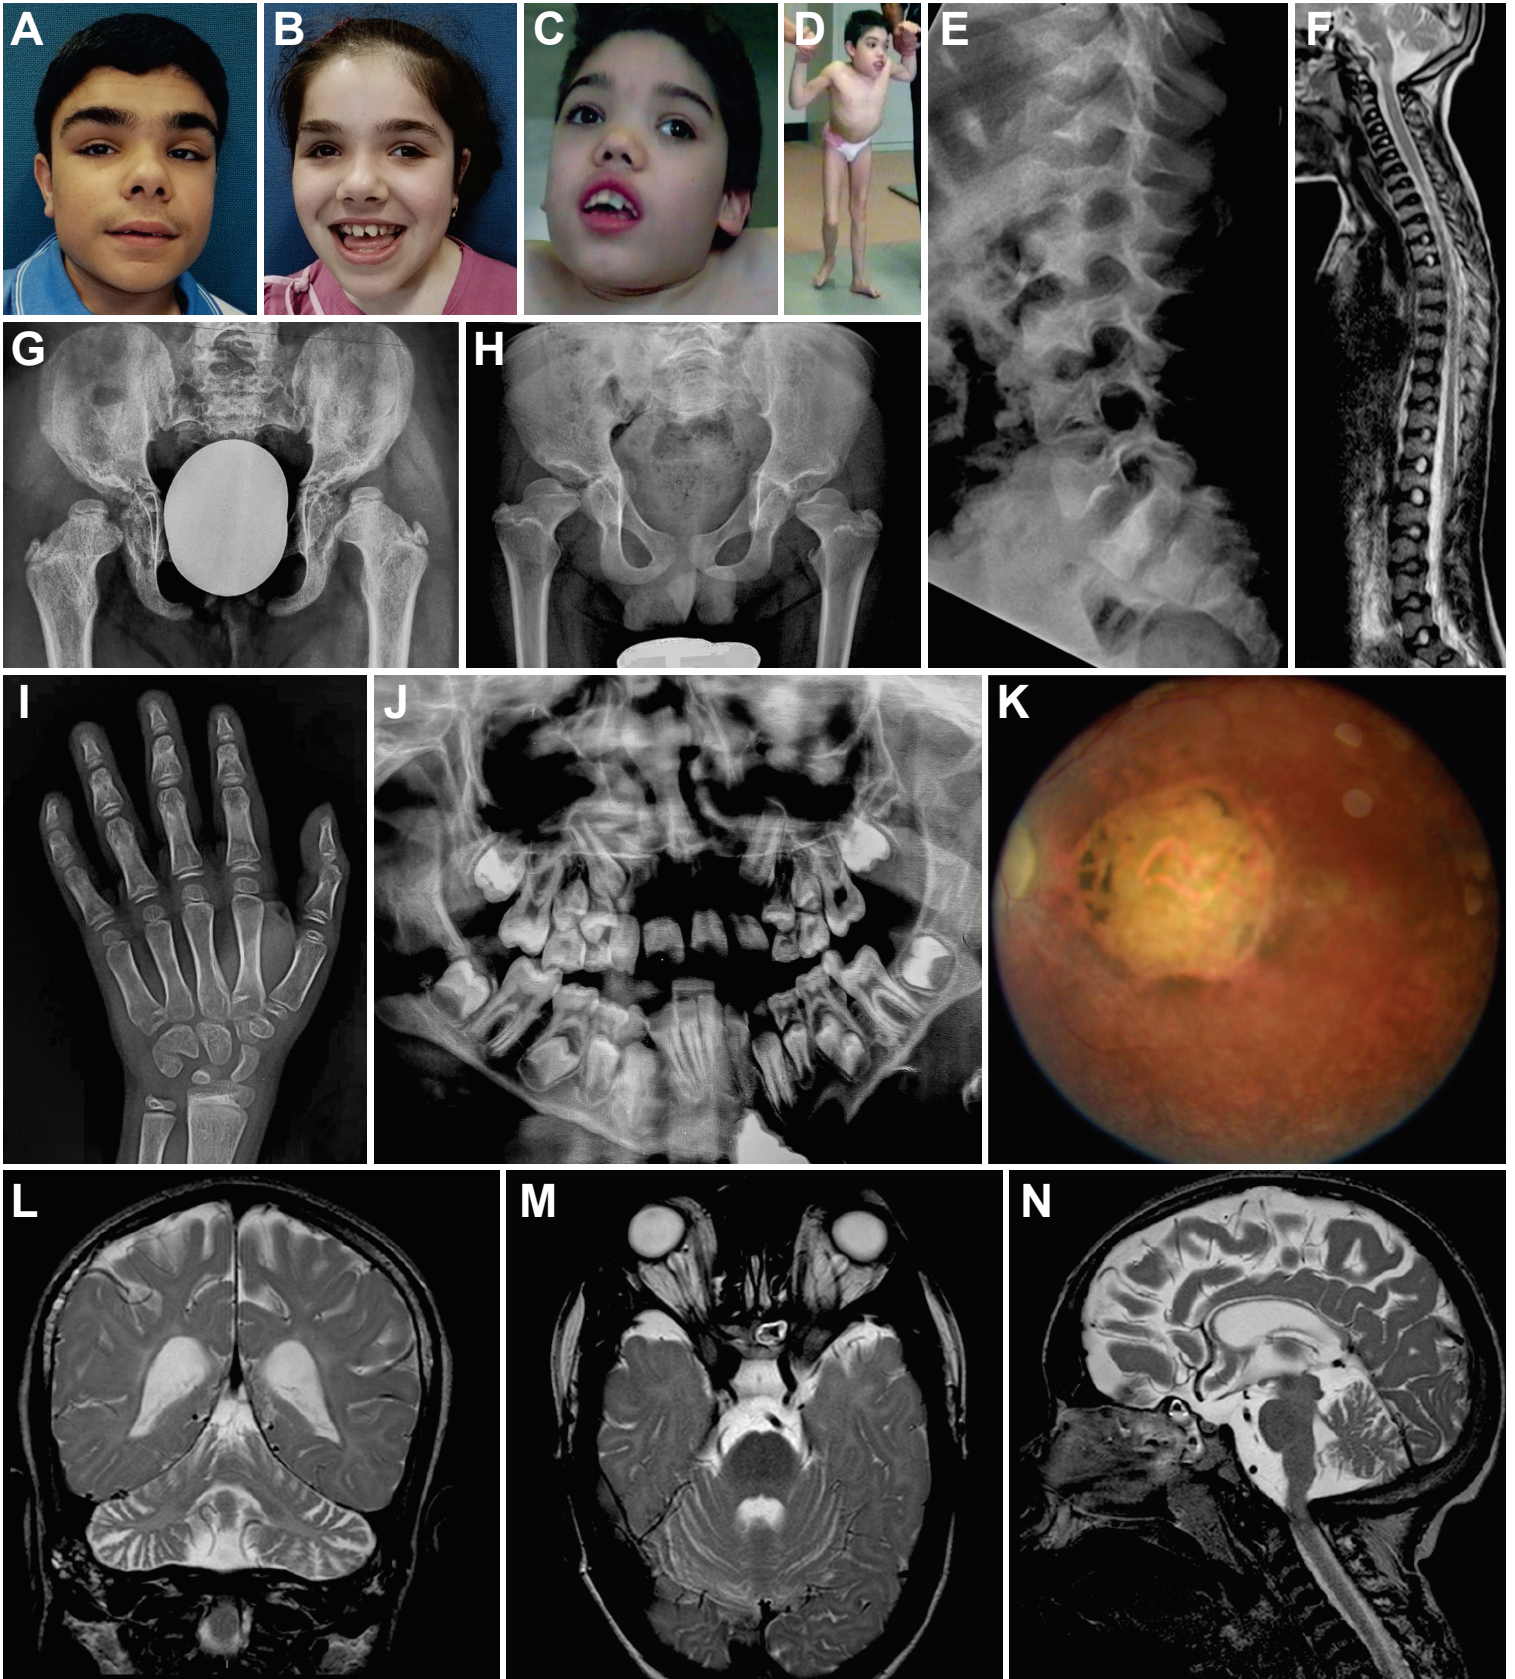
Photographs of patients P1 (A), P2 (B), and P3 (C,D). Facial appearance of the three affected individuals show mild coarsening and a deep nasal bridge. Strabismus is evident in P3, secondary to retinal degeneration. Panel D shows short trunk and signs of lower limb paraparesis. Lateral lumbar spine radiographs of patient P3 (E) and the magnetic resonance imaging (MRI) of patient P1 (F) show the presence of a deep sagittal notch in the center of the vertebral bodies, suggesting that in early childhood there may have been sagittal clefts. The MRI image (panel F) confirms the notching of the vertebral bodies with preservation of a round nucleus pulposus in the intervertebral disks. The cranio-occipital transition does not show signs of stenosis. Pelvic radiographs in panels G (P2, age 6 years) and H (P3, age 11 years) show marked dysplasia of the femoral heads and of the acetabulum. The iliac wings are large and wide. P3's hand x-ray (I) shows mild reduction in the carpal height with dysplasia of the carpal bones. Altogether, these signs are diagnostic for a form of spondylo-epiphyseal dysplasia (SED). Panel J shows a panoramic radiograph of dental abnormalities in P2. Color fundus of the left eye of patient P2 at age 10 (K) shows pale optic disc, marked attenuation of retinal vessels and retinal pigment epithelium dystrophy with macular coloboma. Panels L, M and N show cerebral MRI images of patient P3 at age 13. There is diffused lack of white substance and mild cerebellar atrophy (L, N). We also observe thin optic nerves with a dilated sheath
